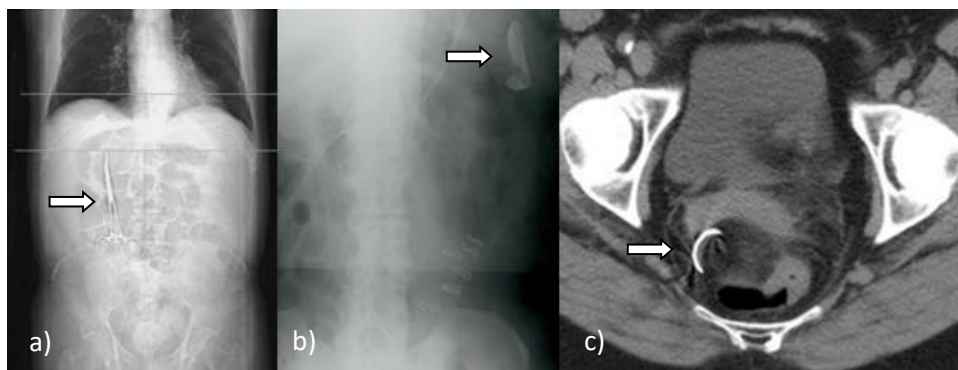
(a) Abdominal radiograph with a retained surgical instrument. (b) Abdominal radiograph with retained gauze. (c) CT scan of the pelvis with a retained needle. The arrow indicates the location of the retained surgical item (adapted from Gibbs et al., 2007).
